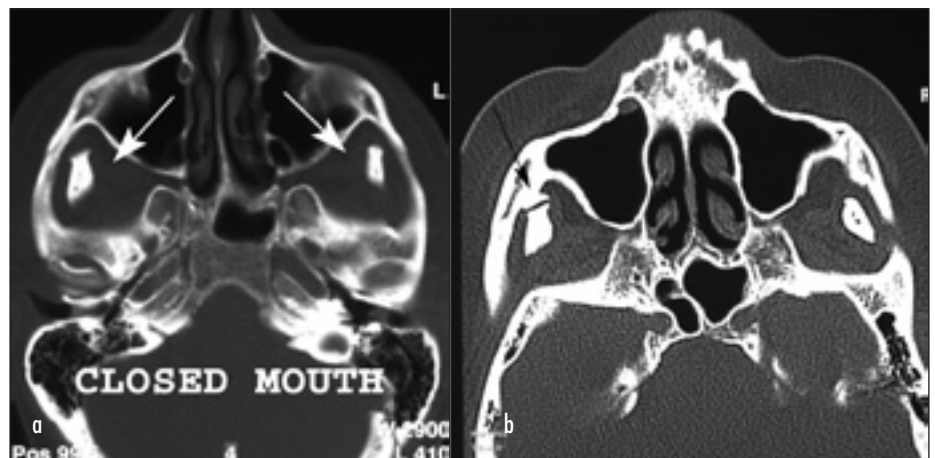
Computed tomography of the mandible. a. In the closed mouth position the coronoid processes are seen above the level of the zygomatic arch (long white arrows). b. In the open mouth position the right coronoid process impinges against the zygomatic arch forming a pseudo joint (long black arrow).
